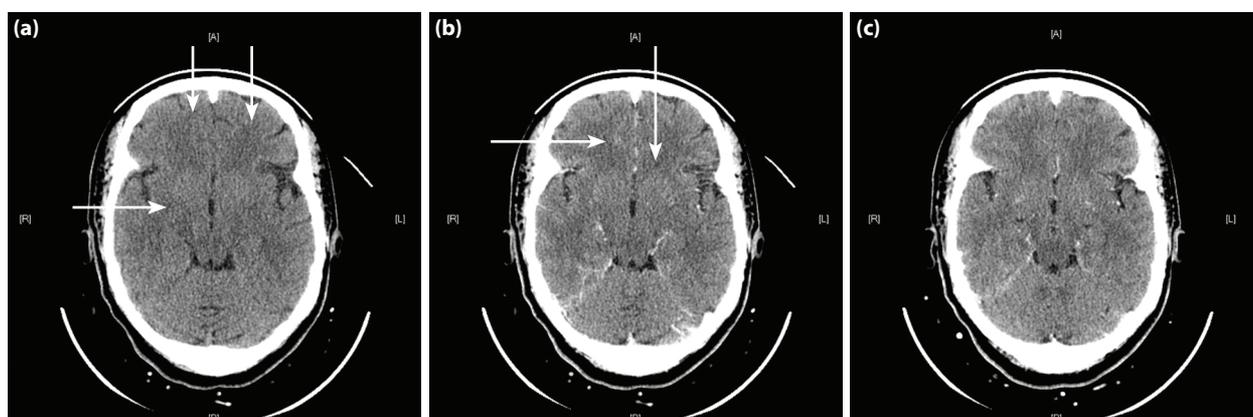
(a) Plain cranial CT scan showing multiple hypodense lesions in the fronto-parietal regions. (b) Contrast cranial CT scan also revealing multiple hypodense lesions in both fronto-parietal regions. (c) Cranial CT demonstrating generalised cerebral edema.
